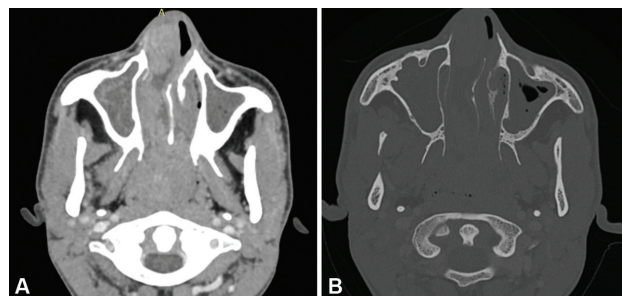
Sinonasal adenocarcinoma. (A) Axial contrast computed tomographic image in soft tissue window shows irregular lobulated mass in the right nasal cavity protruding as far as the anterior choana, and the nasopharynx. Retained secretions in the maxillary sinus noted. (B) Axial bone window image shows destruction of the right turbinate.
